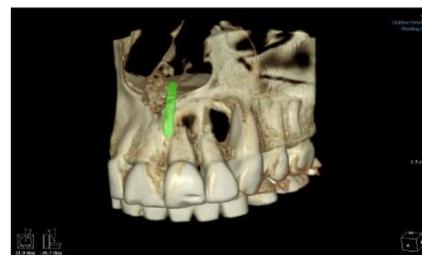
The CBCT scan revealed a osteolytic lesion in the periapical region of teeth 21 and 22
